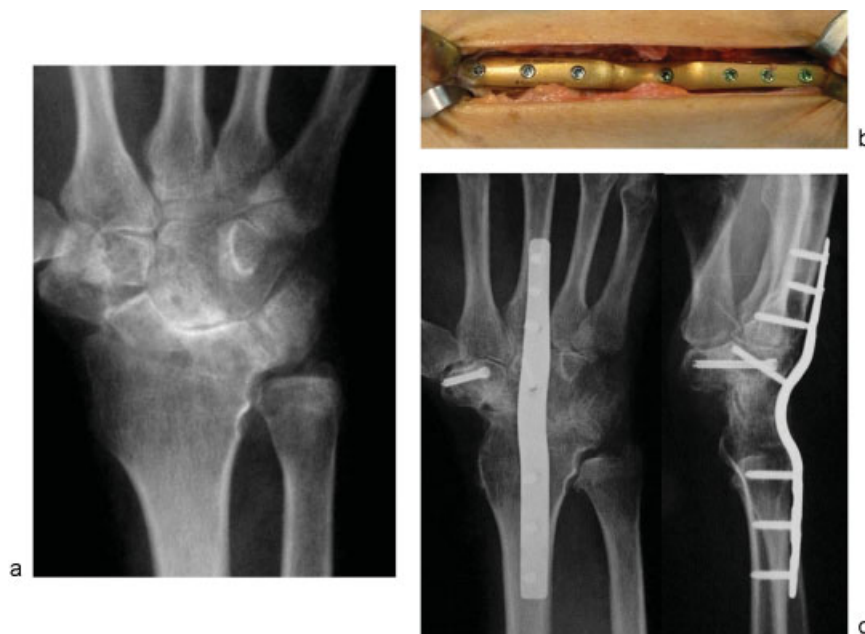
Case 2. (a) Preoperative X-ray image showing the degenerative changes at the midcarpal joint. The distal radioulnar joint remains mobile and painless after 10 years of an ulna shortening. (b) Intraoperative view once the plate has been fixed. The hand is on the right side. All the screws are locked to the plate in round, coaxial holes. (c) Radiological appearance of the fused wrist after 20 months of the index procedure. Plate fitting is excellent on the recipient bones. Size matching is much better than if a standard plate had been used.
